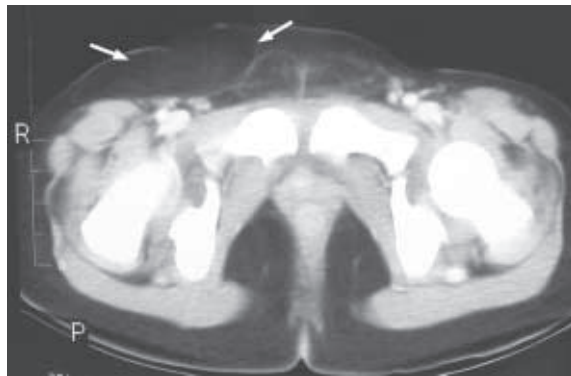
CT appearances of lipoma in a two-year-old girl presenting with a soft tissue lump in the right inguinal region. Enhanced axial CT scan shows a fatty mass (arrows) that blends with the subcutaneous tissue. Diagnosis of lipoma was confirmed at surgery.
